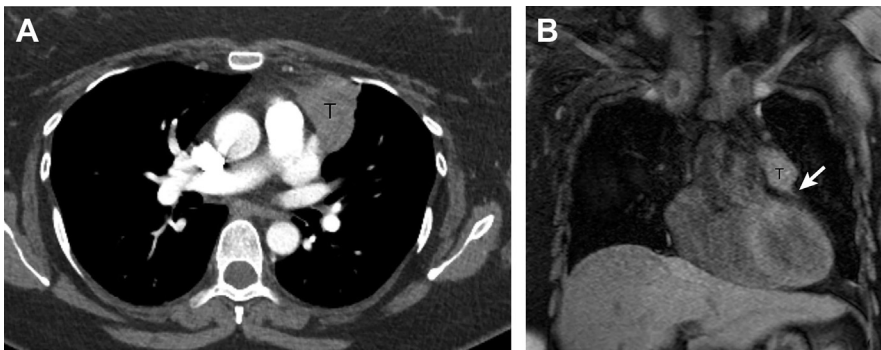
Pericardial Involvement. (A) Contrast-enhanced chest CT scan demonstrates 4 cm anterior mediastinal tumor (T) abutting the pericardium with no obvious pericardial involvement. (B) Coronal axial T1-weighted fast spin echo with fat saturation shows the tumor (T) with extends into the adjacent pericardium (arrow). At surgery a thymic carcinoma involving the pericardium was detected. MRI of the chest is beneficial in challenging cases for assessment of pericardial and cardiac involvement.
